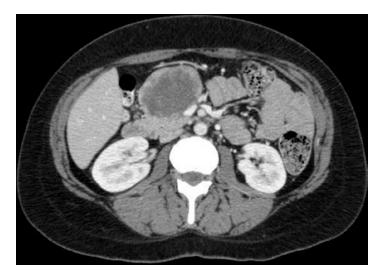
CT scan demonstrating a solid pseudopapillary tumor of the pancreas
